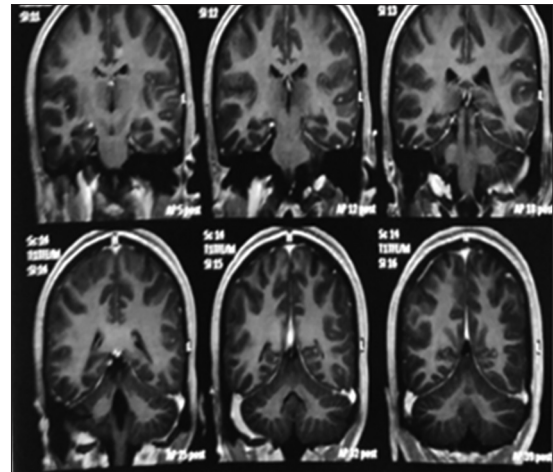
Magnetic resonance imaging brain with contrast suggestive of leptomeningeal enhancement
